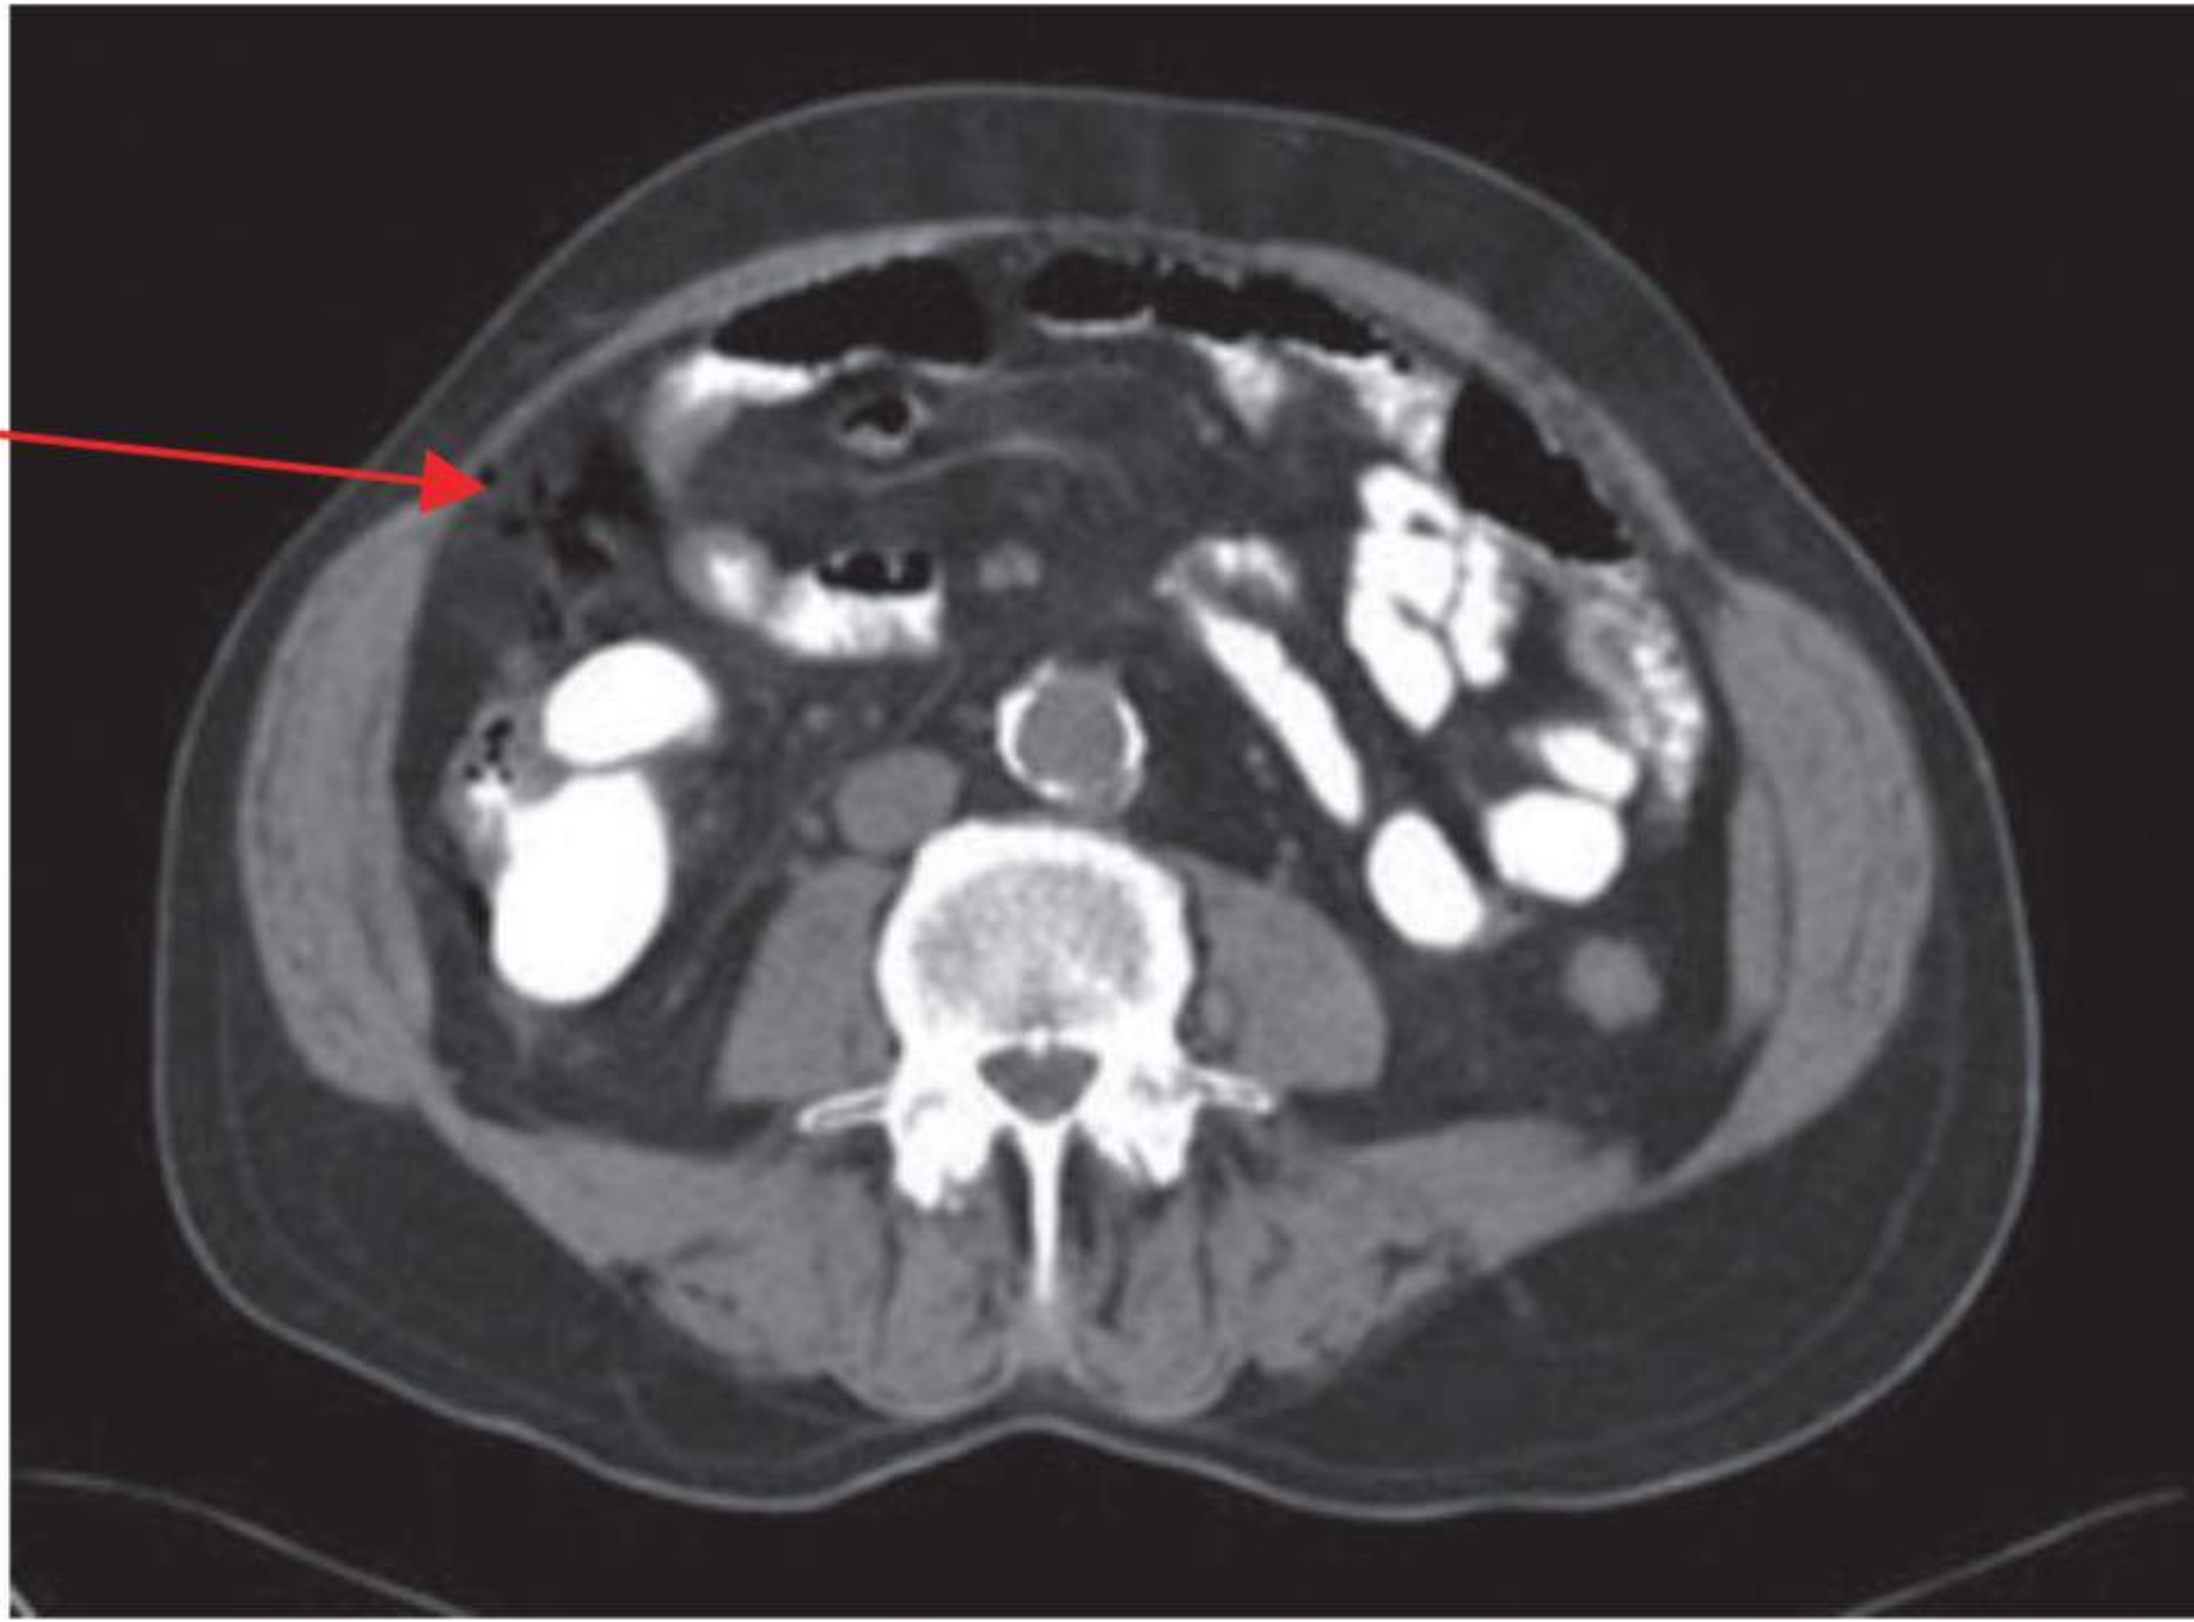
Computed tomographic scan demonstrating free intra-abdominal air following colonoscopic perforation.
